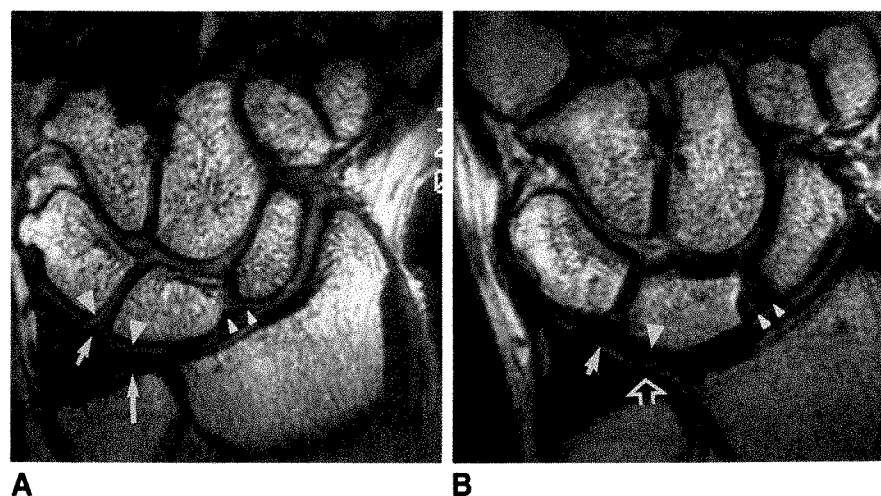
A and B, Coronal MR images of wrist at 1.5-mm slice thickness obtained with two-piece receiver coil. Normal volunteer (A), patient with chronic wrist pain (B). Note good visualization of intact triangular fibrocartilage (long arrow), torn triangular fibrocartilage (open arrow), lunotriquetral ligament (short arrow), scapholunate ligament (small arrowheads), and articular cartilages (large arrowheads).
